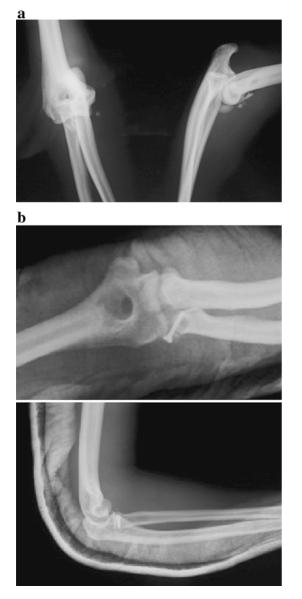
a Pre-operative anteroposterior and lateral radiographs showing a terrible triad injury of the elbow. b Anteroposterior and lateral radiographs showing reconstruction of the comminuted type II coronoid process fracture
